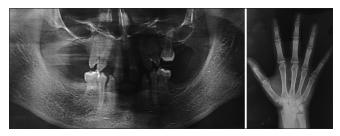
Orthopantomogram and the hand and wrist radiograph of the patient
